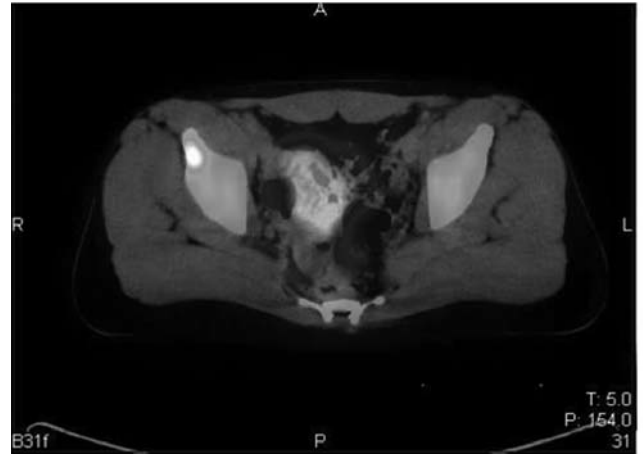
¹⁸Fluoro-deoxyglucose positron emission tomography (¹⁸F-FDG PET/CT) scan detecting a focal FDG uptake.
